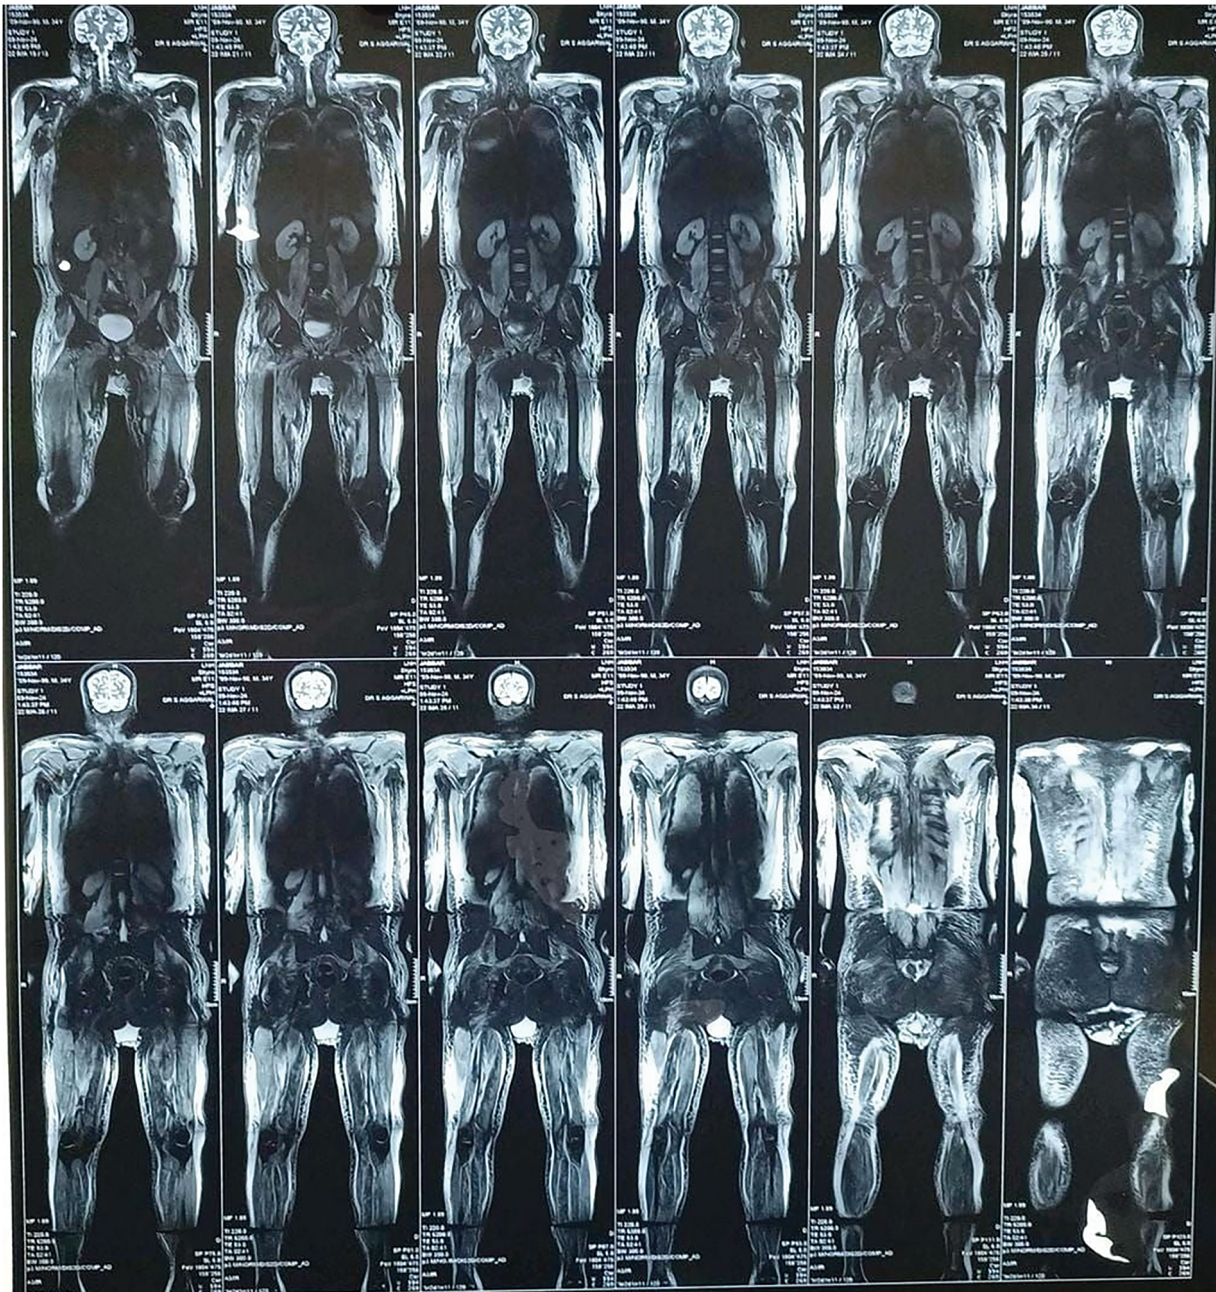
MRI whole body STIR sequence showing symmetric STIR hyperintensity in all the muscles of the body with diffuse subcutaneous edema.
